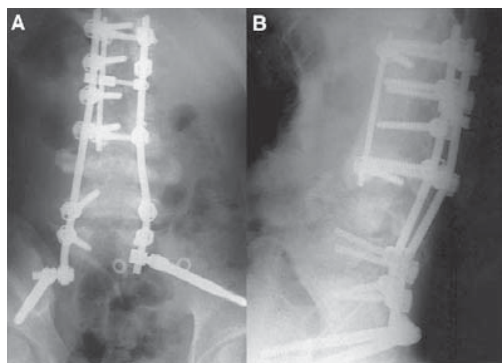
Anteroposterior (A) and lateral (B) radiographic images of the lumbar spine after the second surgical procedure, demonstrating extension of the spinal arthrodesis to include the lumbosacral joint with iliac fixation and resultant restoration of coronal and sagittal spinal alignment.
